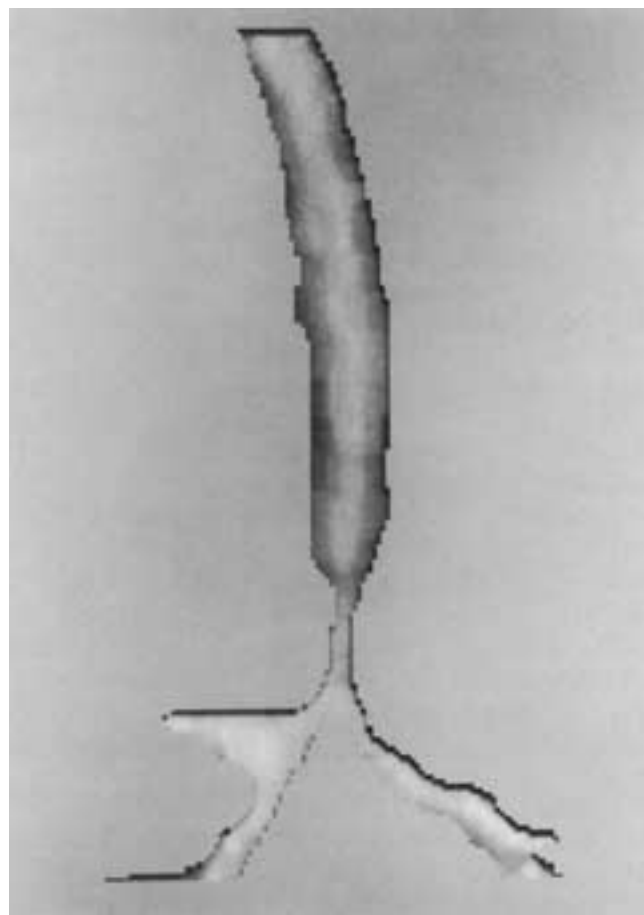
Tracheal stenosis in a newborn with stridor. Three-dimensional reconstructed images of the trachea and carina were obtained using a segmentation technique. T1-weighted axial images were obtained of the airway, and then coronal reformations confirmed the tracheal narrowing and best showed the cranial-caudal extent of the luminal compromise. The length of the narrowing was not appreciated at endoscopy because the endoscope could not pass through the narrowed segment.
